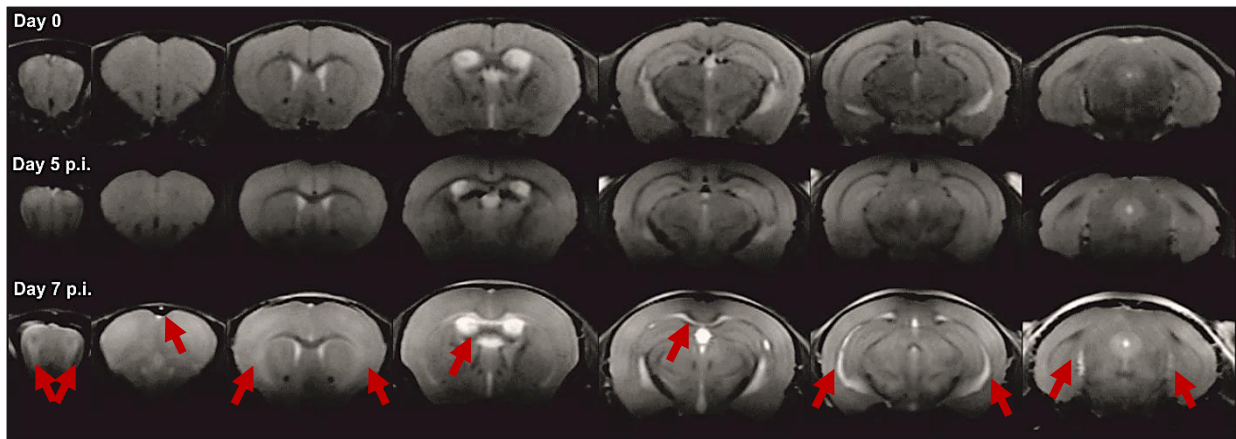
T2-weighted MR anatomy images showed development of severe edema at day 7 p.i. Red arrows point to regions of increased signal intensity observed only at day 7 p.i. indicating development of severe edema at a late time point in disease development, especially in the white matter fibre tracts.
